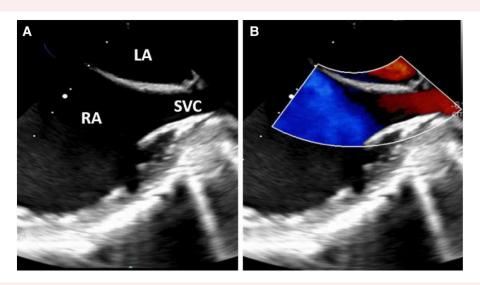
Transoesophageal echocardiography post-atrial septal defect closure. Two-dimensional (A) and colour-Doppler (B) transoesophageal echocardiography; LA, left atrium; RA, right atrium; SVC, superior caval vein.
